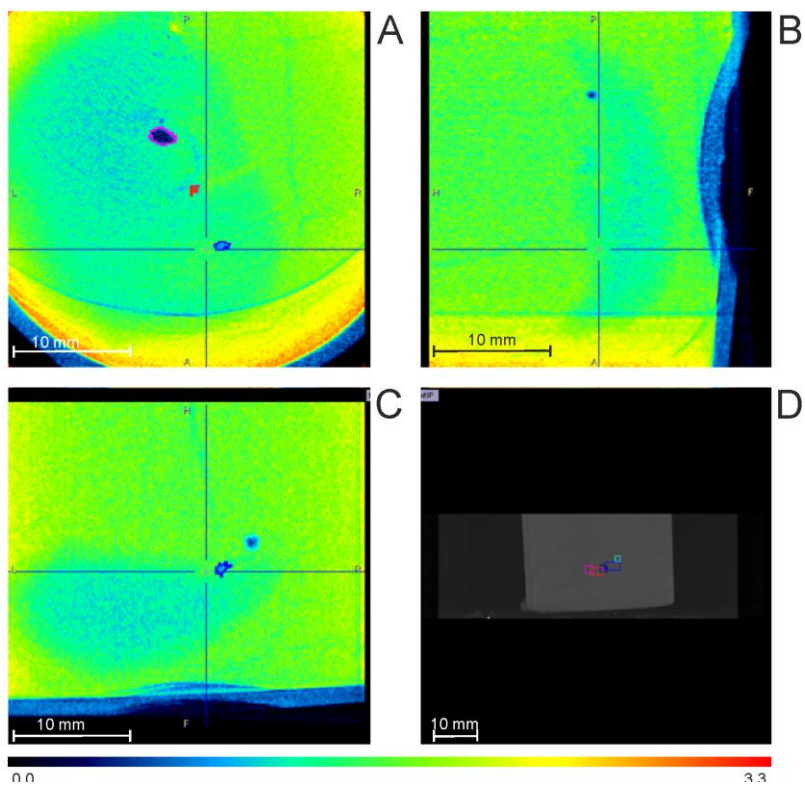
CT image of a slice of the kidney B, loaded to 55% v/v Me_2SO , in which has been inserted four drops of water and then cooled to $-196\text{ }^\circ\text{C}$. The image was taken at $-140\text{ }^\circ\text{C}$. The image uses the cold scale and the spatial resolution is $100\text{ }\mu\text{m}$
